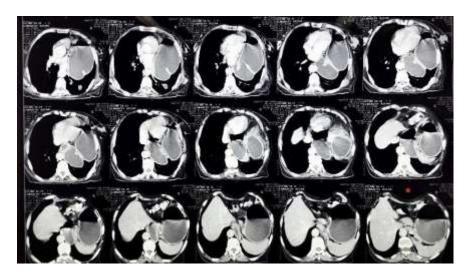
CT image showing stomach in left thoracic side
